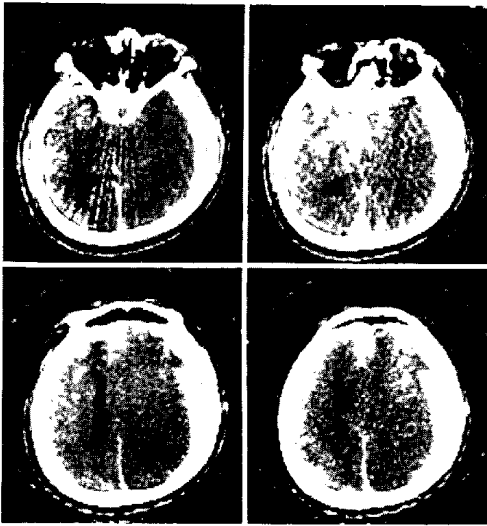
Subdural hematoma. 52-year-old male. CT was performed 2 hours after trauma. A typical crescent-shaped high density area is seen on the right side. The right lateral ventricle is compressed and cannot be seen. All basal cisterns cannot be identified. Angiogram showed non-filling phenomenon.
